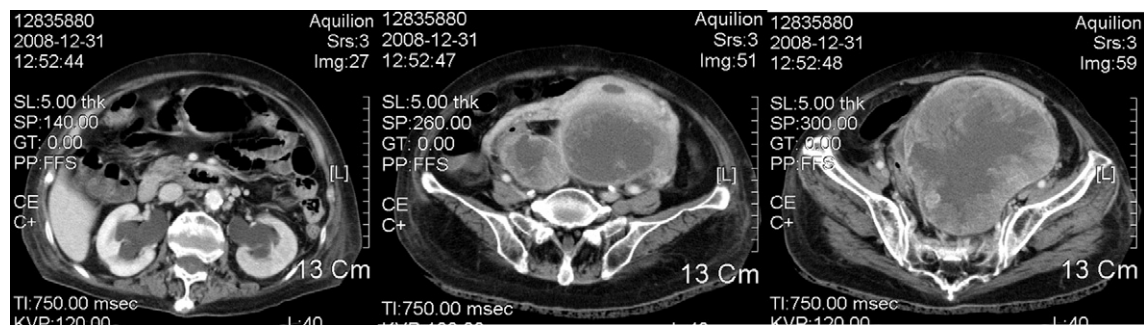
Computed tomography of the abdominal region shows bilateral hydronephrosis, fluid accumulation in the uterus, a right adnexa tumor mass, and a large necrotic tumor (about 15 cm in size) between the uterus and the rectum. No obvious retroperitoneal lymph nodes could be identified.
